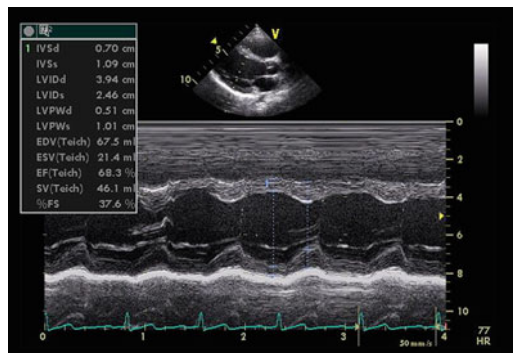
Echocardiographic parasternal long axis view of the left ventricle (Source: <http://en.wikipedia.org/wiki/Echocardiography>)
